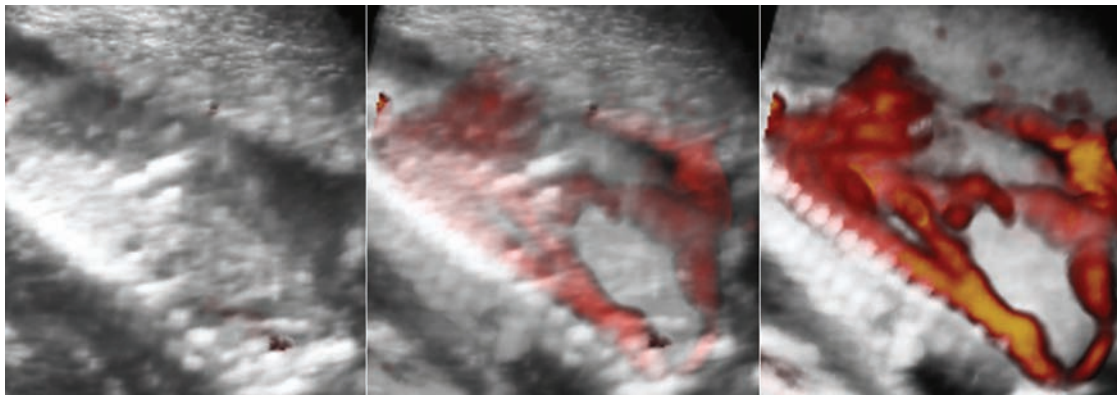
A longitudinal view of the abdomen seen from the right side in glass body mode. From left to right the transparency is gradually increased allowing a progressive visualization of power Doppler information.
